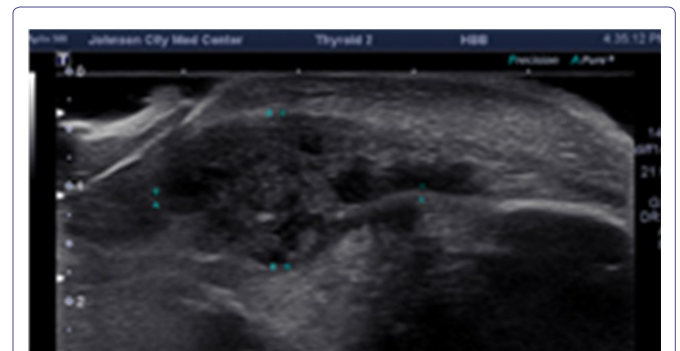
Grayscale sonographic image of the right parotid region.
